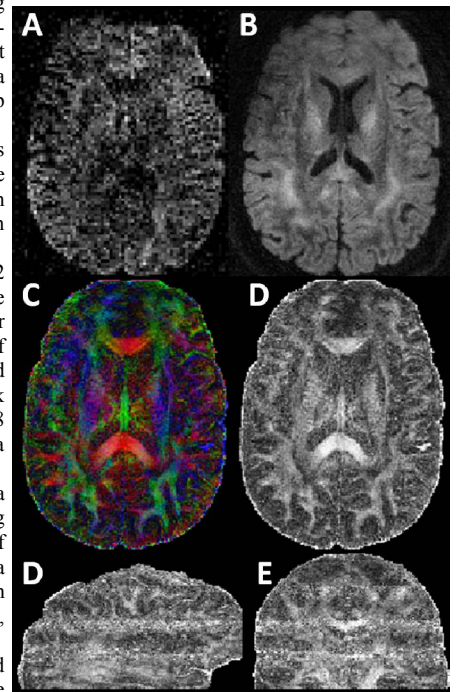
DWI from a 2mm EPI sequence (A) and a 1mm 3D approach (B). FA maps from 6 directions of diffusion encoding for the 3D 1mm sequence (C-E)
